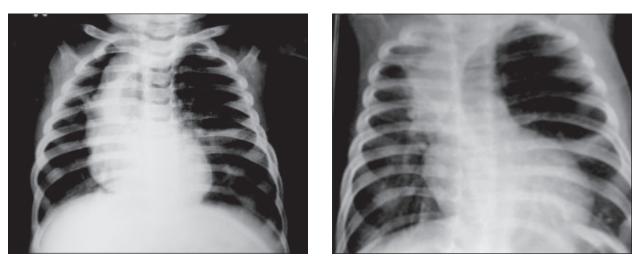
X-rays show CLE of left upper lobe.
